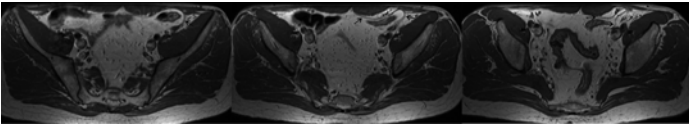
Axial MR T1-weighted images of laparoscopic mesh (*black arrows*) placed with a transabdominal preperitoneal (TAPP) approach.
